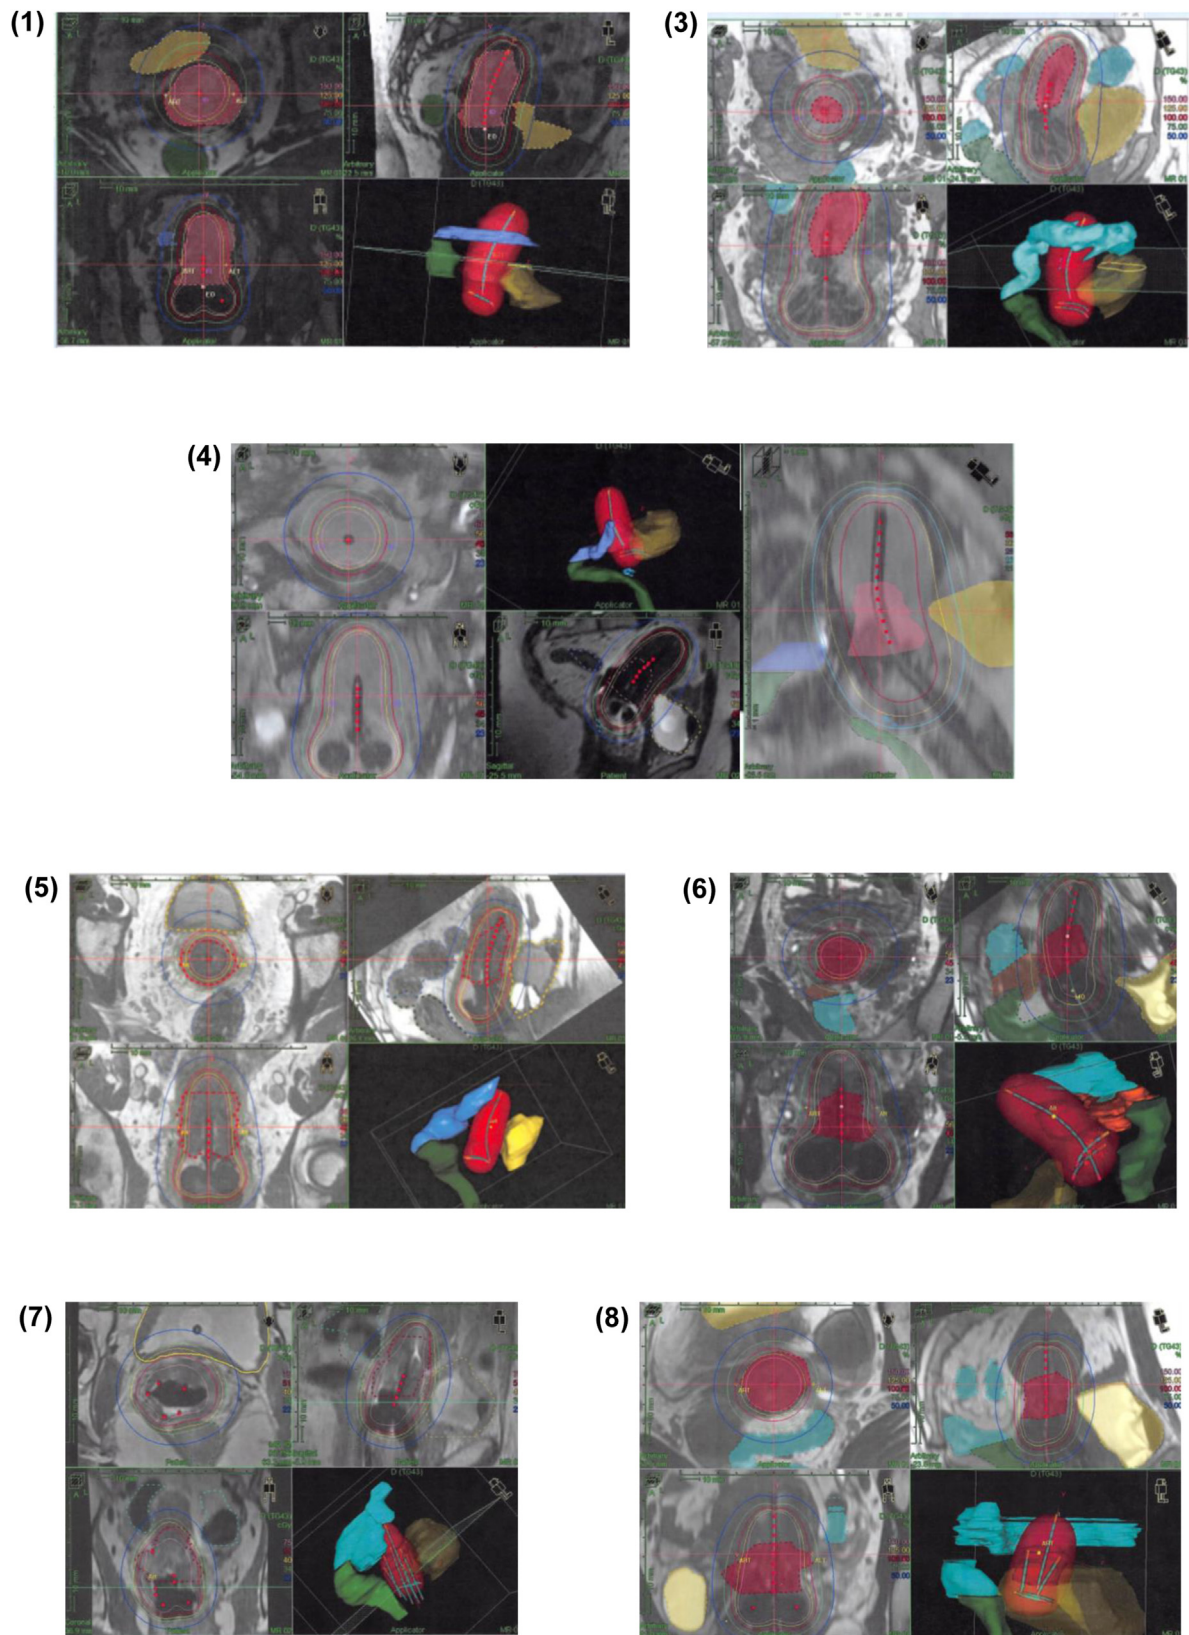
Example pulsed-dose-rate (PDR) gynecologic brachytherapy treatment plans, generated directly on postimplant MRI (Oncentra planning system, Elekta, Stockholm, Sweden) with C4:S line markers inserted within the applicator tandem-and-ovoids and interstitial catheters (cases 7 and 8). Labeled by case number.
